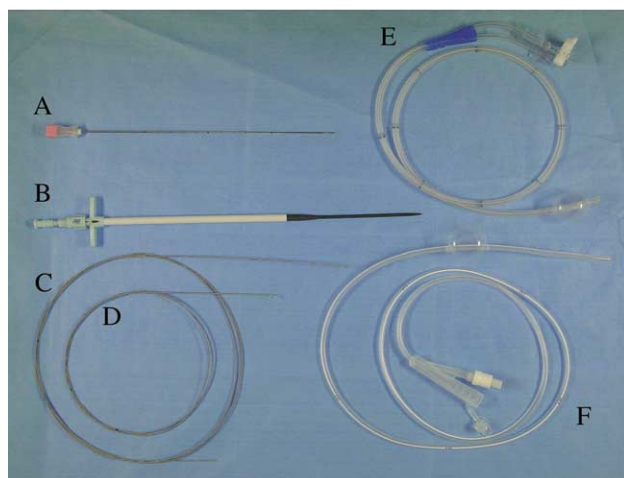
Percutaneous transesophageal gastrostomy (PTEG) device kit. (A) Needle with sheath. (B) Dilator with peel-away sheath. (C) Straight guidewire (first guidewire). (D) Angled guidewire (second guidewire). (E) Rupture-free balloon. (F) PTEG catheter.
